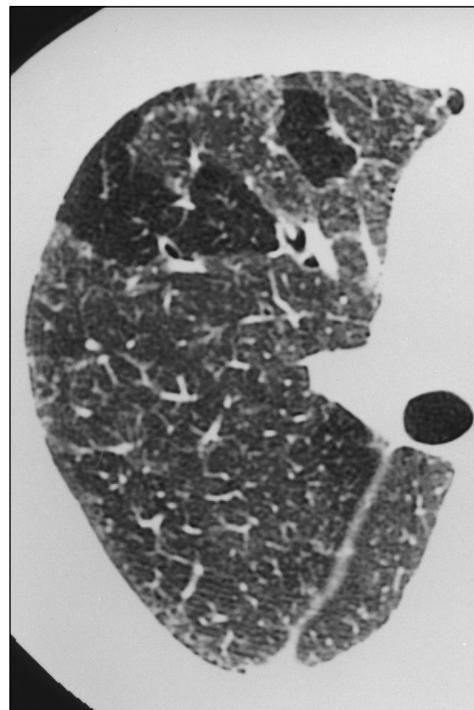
High-resolution CT scan obtained in 81-year-old man with asbestosis shows mosaic perfusion.
